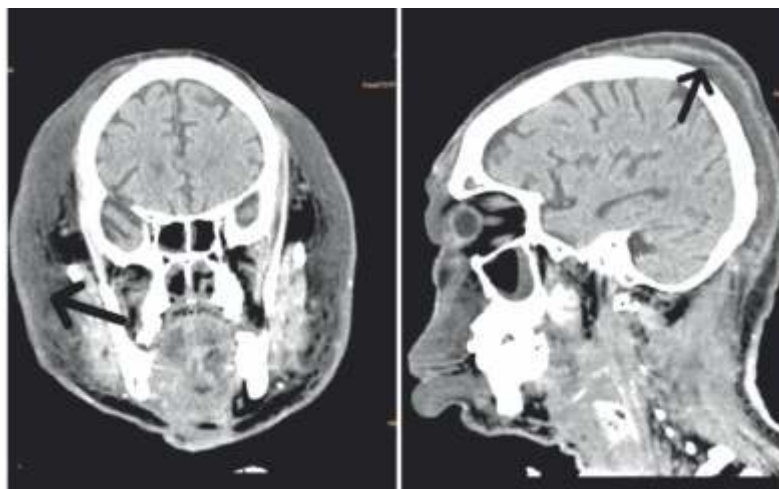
CT images of thickened skin with subcutaneous edema of the scalp and face (black arrow)
